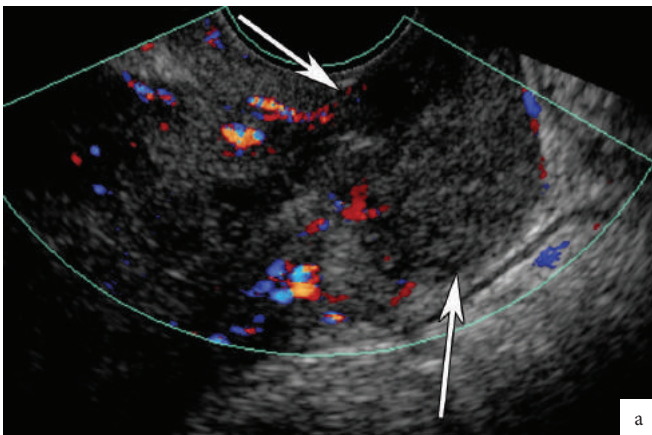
Sagittal endovaginal ultrasound showing an ill-defined mass in the cervix (arrows).
